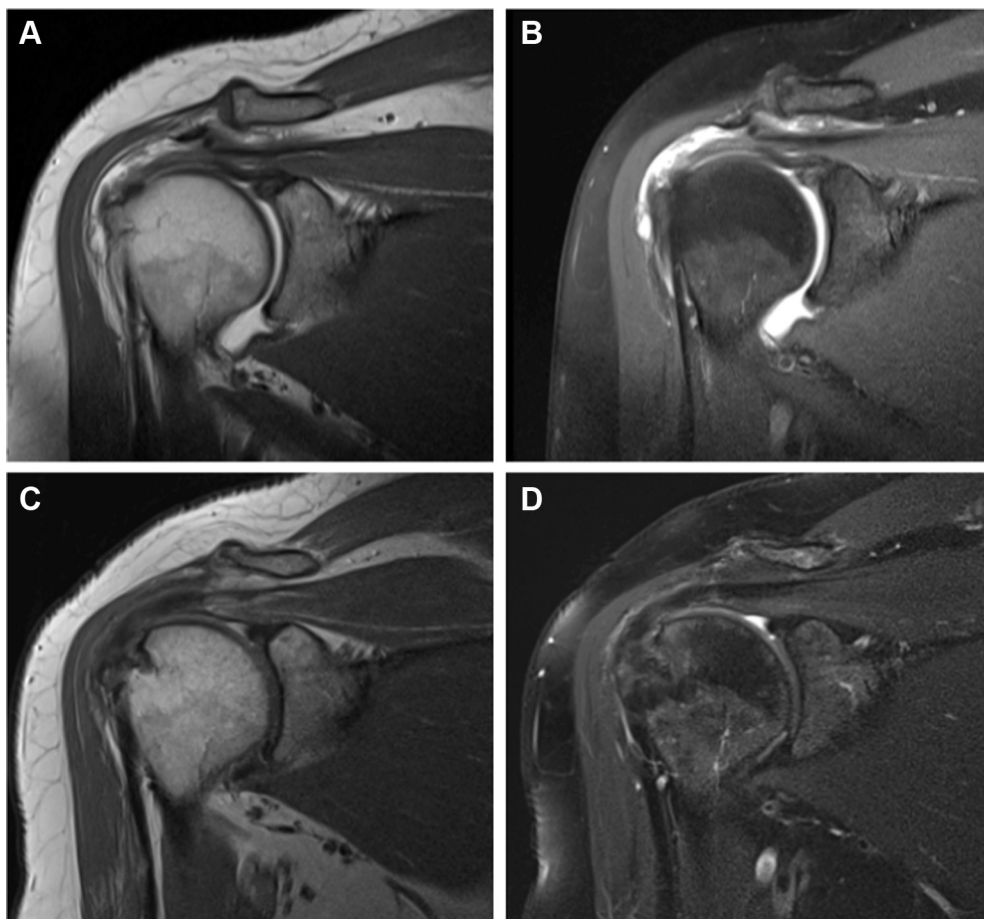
(A, B) Preoperative paracoronal magnetic resonance imaging preoperative with large L-shaped tear and significant fraying of superficial layer of supraspinatus. (C, D) Corresponding 1-year postoperative magnetic resonance imaging with full structural integrity Sugaya I. Note that the patch is radiographically indistinguishable, representing full resorption of the patch.
